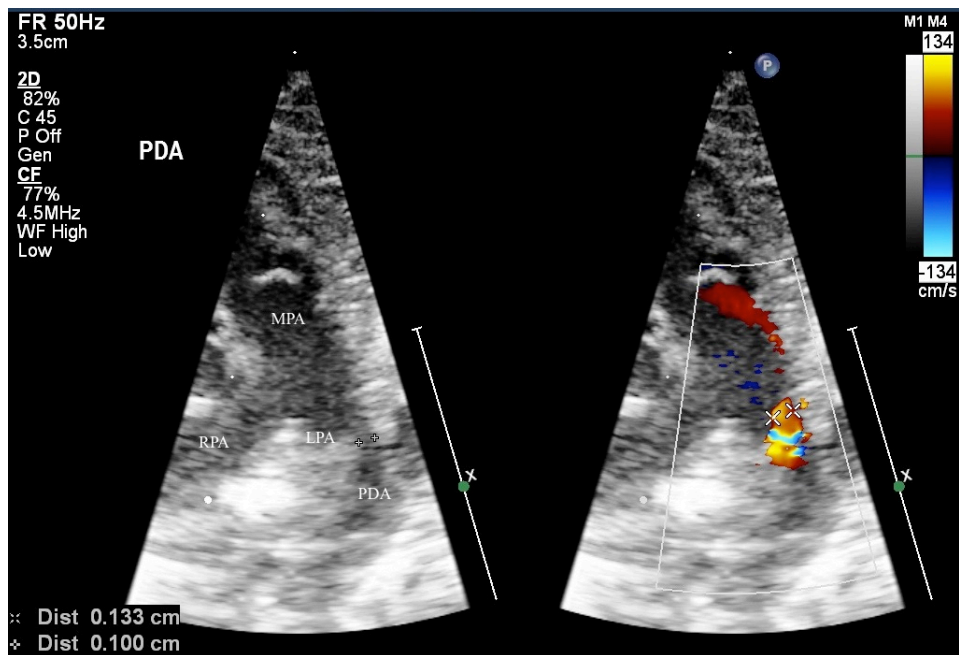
Figure showing the two-dimensional and colour Doppler view of the patent ductus arteriosus obtained from the short axis view. MPA –main pulmonary artery, RPA –right pulmonary artery, LPA –left pulmonary artery, PDA –patent ductus arteriosus.
